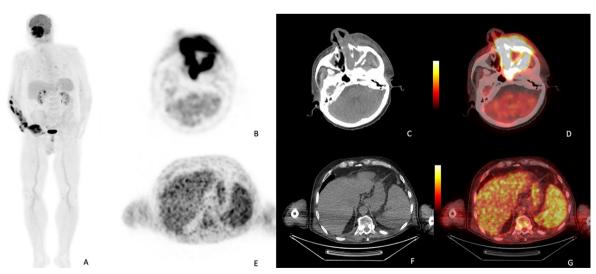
The whole body PET scan of the patient: maximum intensity projection image (MIP) increased metabolic activity in the face, the right forearm and hand (A). The first line; transaxial section of the face showing involvement around maxillary sinus and face skin, B) (emission), C) (computerized tomography), D) (PET/CT fusion) images, the second line: Transaxial section of liver and enlarged spleen. Splenic metabolic activity is increased compared to the liver. E) (emission), F) (computerized tomography), G) (PET/CT fusion) images.
